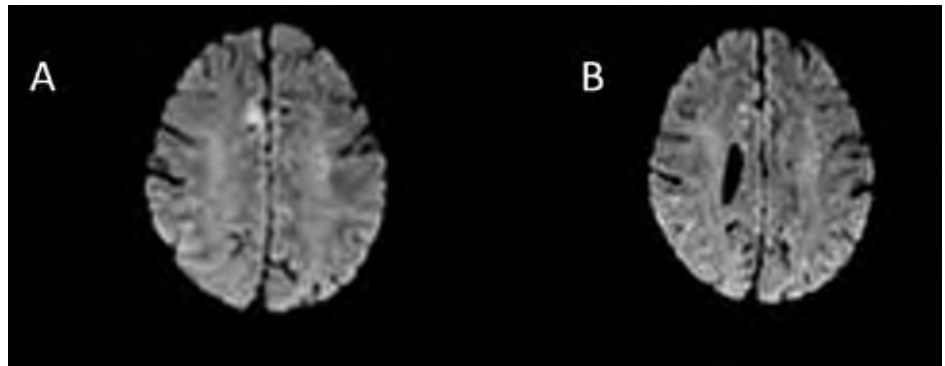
Demonstrates hyperintensity on DWI sequence (A and B) in the right parafalcine region.
